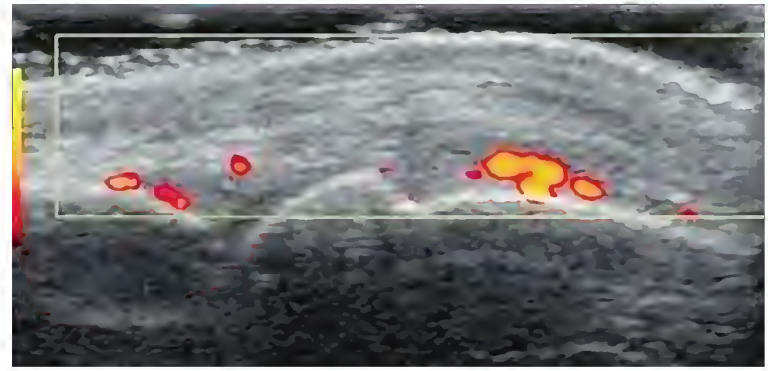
Baseline musculoskeletal sonogram of the second metacarpophalangeal joint. Power Doppler ultrasonography shows positive results with synovial hypertrophy plus effusion. (From Valentini G, Cuomo G, D'Abrascia V, Cappabianca S. A scleroderma patient with swollen and tender joints of both hands. In: Silver RM, Denton CP, editors. *Case studies in systemic sclerosis*. London: Springer-Verlag; 2011, p. 239-50.)
